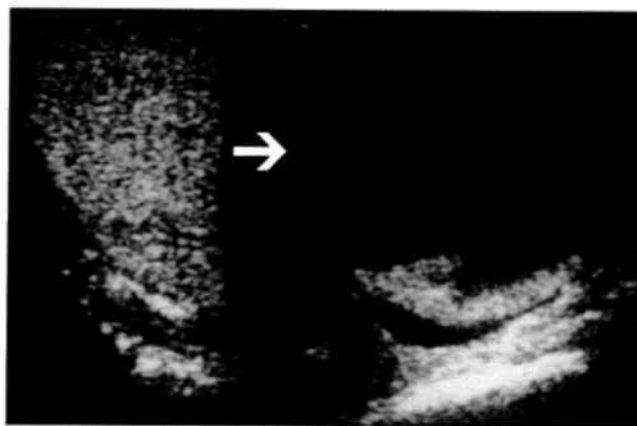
Transverse image of scrotal ultrasound revealing large left testicular cyst and small rim of normal appearing testis. Right testis is normal.
